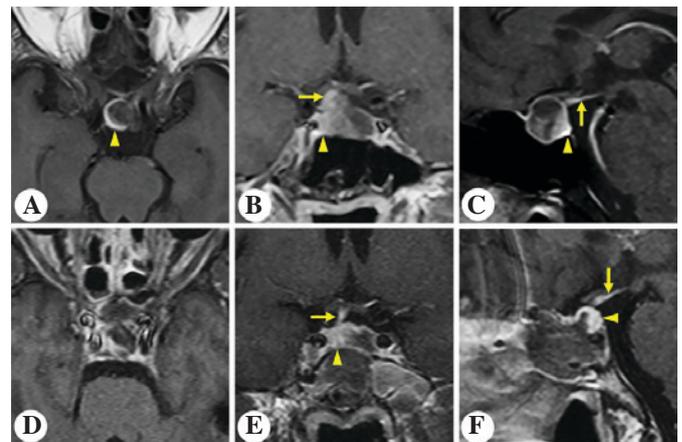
Patient 1. Representative post contrast T1-weighted images. Preoperative (A) horizontal, (B) coronal and (C) sagittal MRI images demonstrated the space-occupying lesion in the sellar region. Postoperative (D) horizontal, (E) coronal and (F) sagittal MRI images showed gross-total resection of the tumor and the anatomically intact pituitary stalk and gland. Arrows indicate the pituitary stalk. Arrowheads indicate the pituitary gland. MRI, magnetic resonance imaging.
